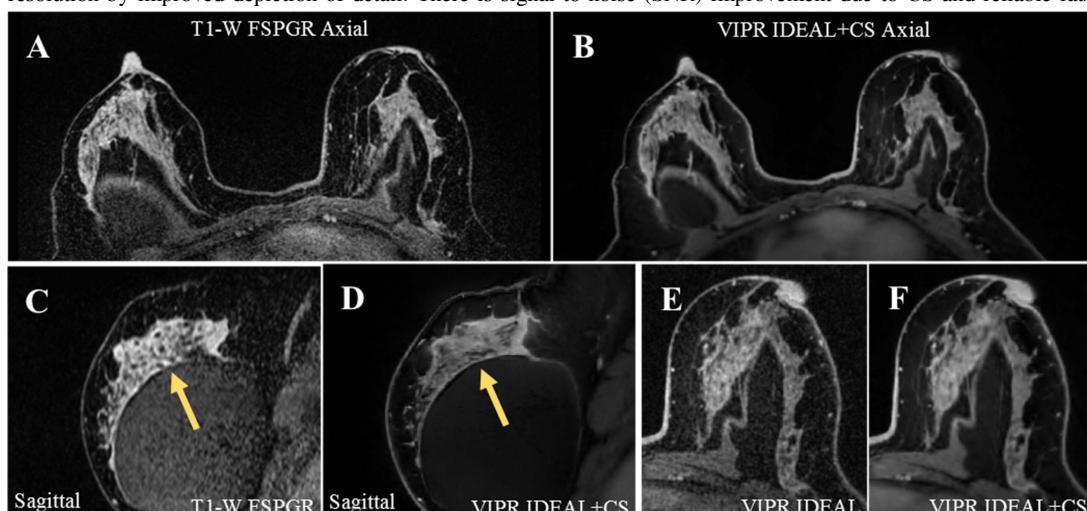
A, C) Axial and Sagittal T1-Weighted FSPGR MRI with two-point Dixon fat separation in a patient with silicone breast implants. B, D, and F) Bilateral axial and sagittal VIPR IDEAL with compressed sensing provides complete fat removal and thus high contrast with fibroglandular tissue. (D) Noise due to undersampling in VIPR IDEAL (E) is minimized with CS (F).
